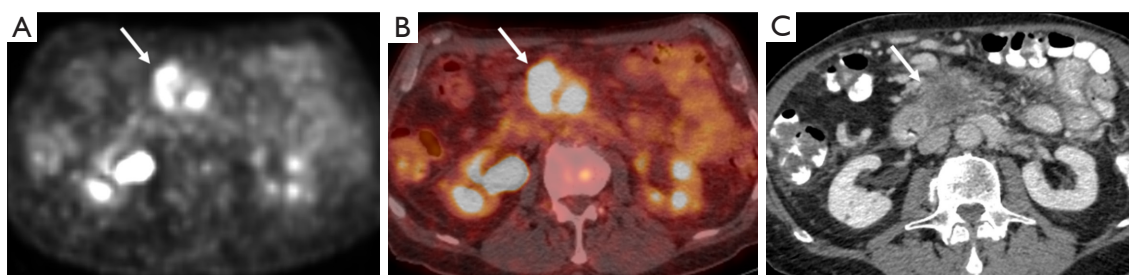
PET and CT of pancreas head mass. (A) Attenuation corrected PET, (B) fused imaged, and (C) corresponding venous phase CT image from exam 1 day prior demonstrate a hypermetabolic pancreas head mass (arrows) with SUV of 8.3 in a 79-year-old man. PET, positron emission tomography; CT, computed tomography; SUV, standardized uptake value.
